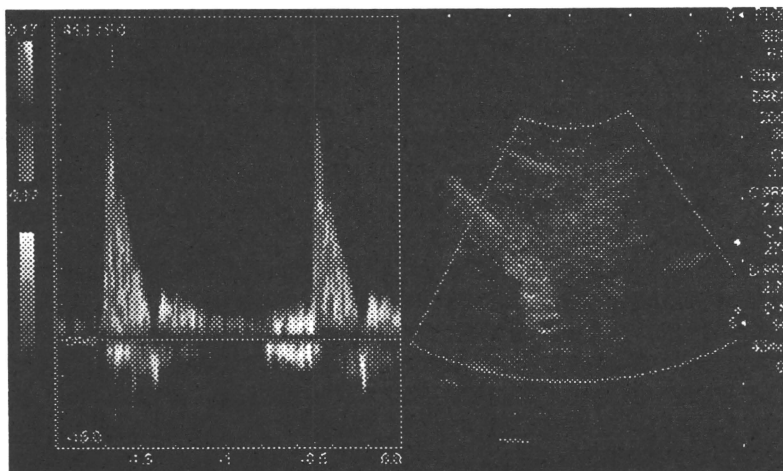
The image of the intercostal artery (right), and the pulsed-Doppler pattern consists of systolic, diastolic notch, and diastolic (left).
